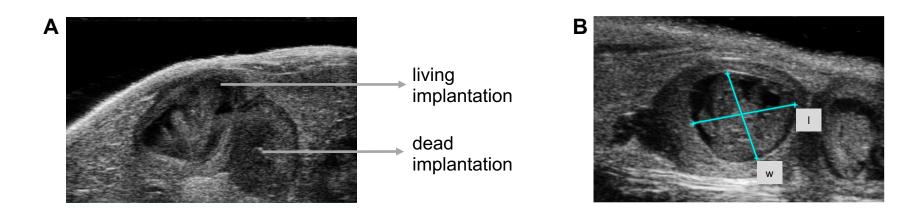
Ultrasound imaging
